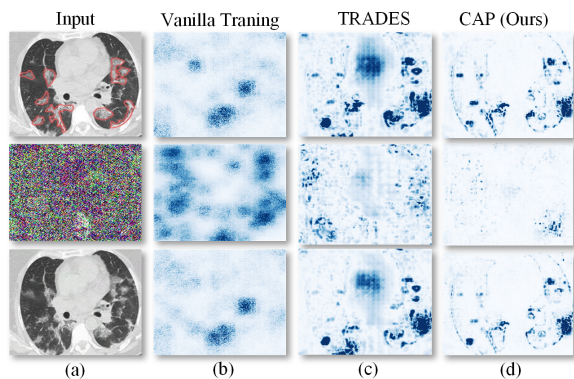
Saliency map (Simonyan, Vedaldi, and Zisserman 2013) of three models under different training strategies. Top: Original COVID-19 positive CT scan with expert annotations. Middle: Adversarial noise generated by projected gradient descent (PGD). Bottom: Image under attack. All the models using (b) vanilla training, (c) TRADES and (d) CAP have correct prediction in clean samples, while only the last two models stay robust in adversarial case.
